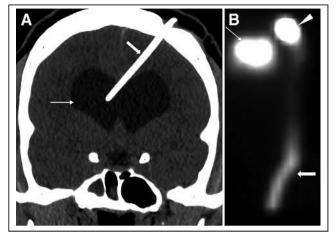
(A) Coronal CT of head shows hydrocephalus (thin arrow) and left frontal approach ventricular shunt catheter terminating in right ventricle (thick arrow). (B) Planar scintigraphy in anterior projection shows injected activity in shunt reservoir on left scalp (arrowhead). Activity is seen in lateral ventricles (thin arrow) suggestive of patent proximal tubing. Activity is seen tracking through distal tubing along chest and upper abdomen (thick arrow).
